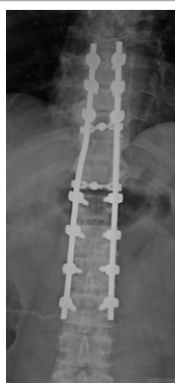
A postoperative radiographic image shows a posterior decompression with laminoplasty extending from T7 to L3.
